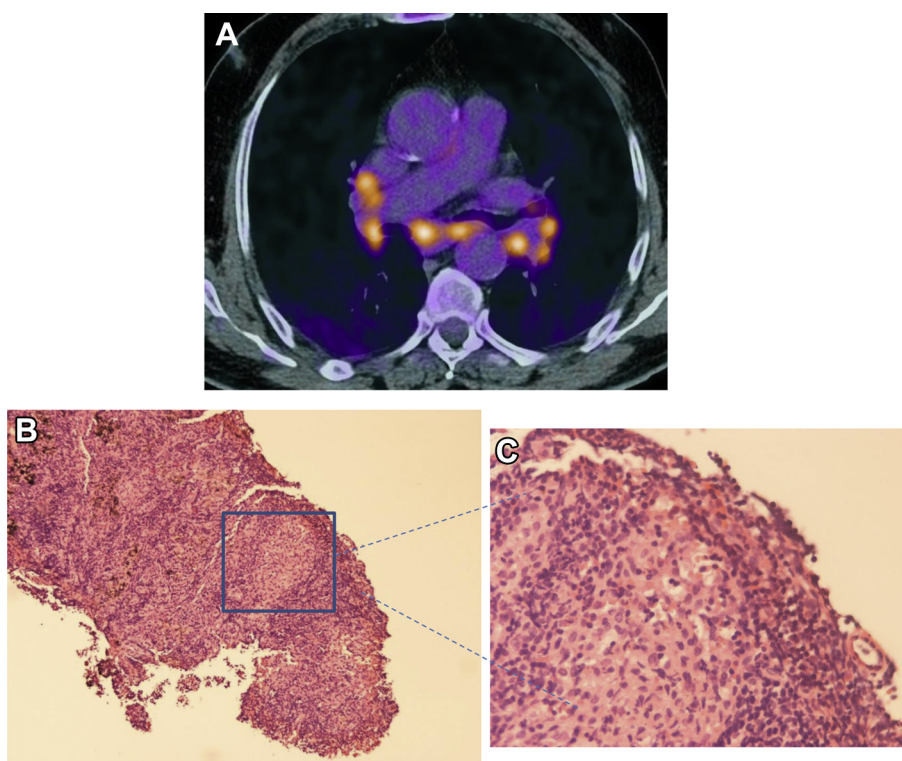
A-C, A 55-year-old man received pembrolizumab for metastatic melanoma, 200 mg IV every 3 wk. Restaging after four doses of pembrolizumab revealed regression with a near-complete response at most tumor locations with fludeoxyglucose positron emission tomography/CT imaging. However, follow-up fludeoxyglucose positron emission tomography/CT imaging also showed new highly metabolic active enlarged mediastinal and bilateral hilar lymph nodes (A). Endobronchial ultrasound-guided biopsy revealed focal infiltration by noncaseating granulomas (40× magnification [B]; 400× magnification [C]). PET/CT imaging was repeated 4 mo later after pembrolizumab therapy had been completed and showed complete remission of the melanoma and disappearance of the elevated metabolic activity of the mediastinal/hilar lymph nodes. This case meets the criteria for a pembrolizumab-associated drug-induced sarcoidosis-like reaction.
